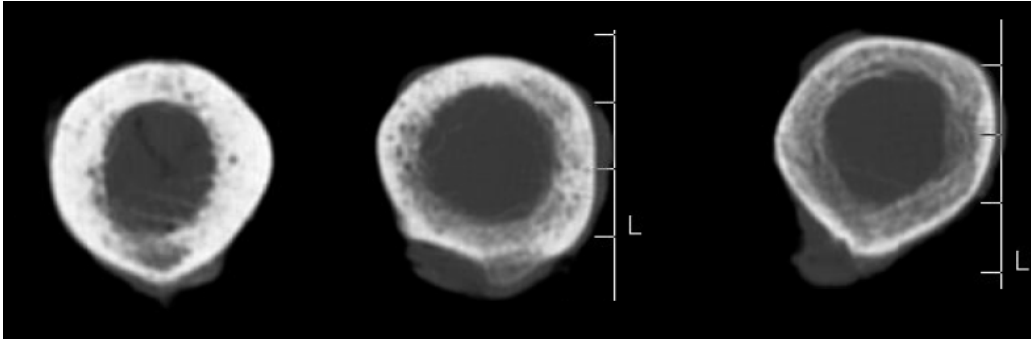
CT scans of the three femurs exhibiting different densities respectively from left to right F1, F2, F3.
